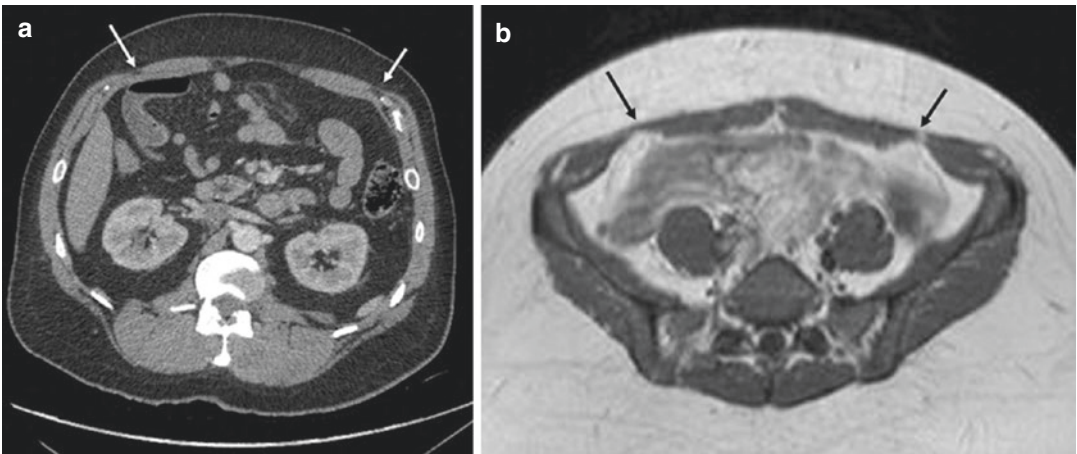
(a) Computer tomography cross-sectional (axial) image with white arrow pointing to linea semilunaris on both sides. (b) Cross-section MRI image of abdomen with black arrows pointing to the linea semilunaris on both sides
